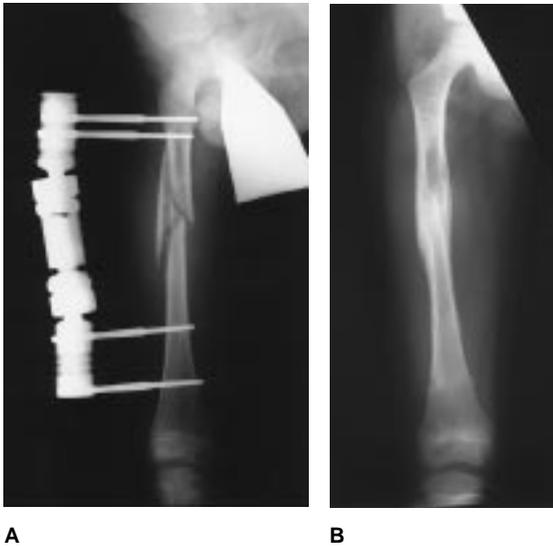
A, Radiographs obtained 2 weeks after external fixation of a comminuted femoral-shaft fracture in an 8-year-old child. B, Four months after the fracture, immediately after removal of the external fixator, fracture is seen to be healed in good position.
